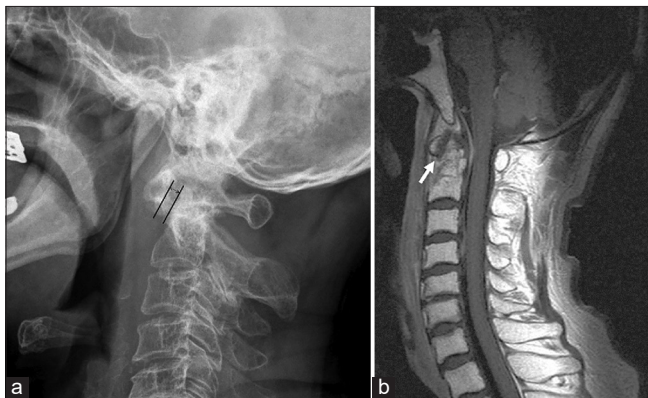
(a) X-ray lateral view cervical spine shows straightened curvature of cervical vertebra, and widened atlantodental interval, measuring 4 mm (gap of double head) (Grisel's syndrome), (b) T2-weighted sagittal view of cervical spine magnetic resonance imaging shows a widened atlantodental interval with heterogeneous hypointensity (white arrow) (Grisel's syndrome)
